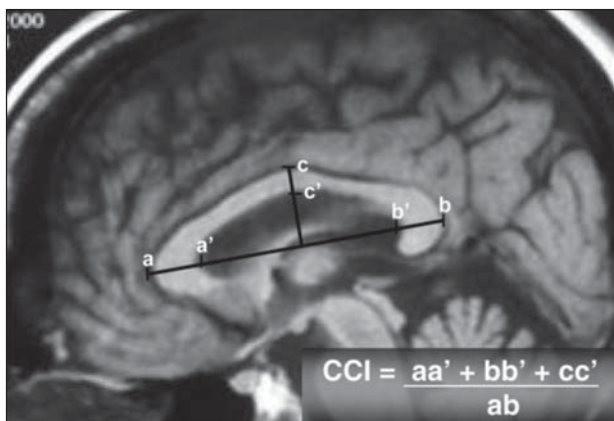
Determination of corpus callosum index, using a "best" midsagittal slice on a T1W brain MRI.
